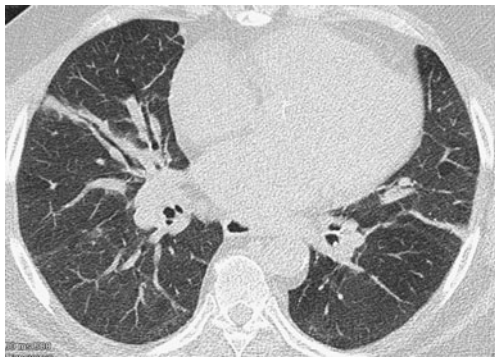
Band like pattern. A 70-year-old woman presented with breathlessness, HRCT image through the mid zones demonstrates band like opacities extending to the pleura, some containing prominent air bronchograms. OP was diagnosed and the symptoms resolved following steroid treatment
